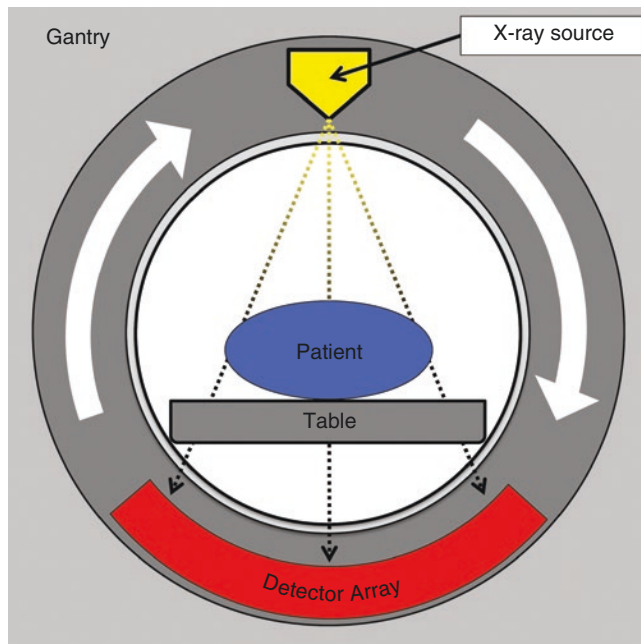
Anatomy of a CT scanner
